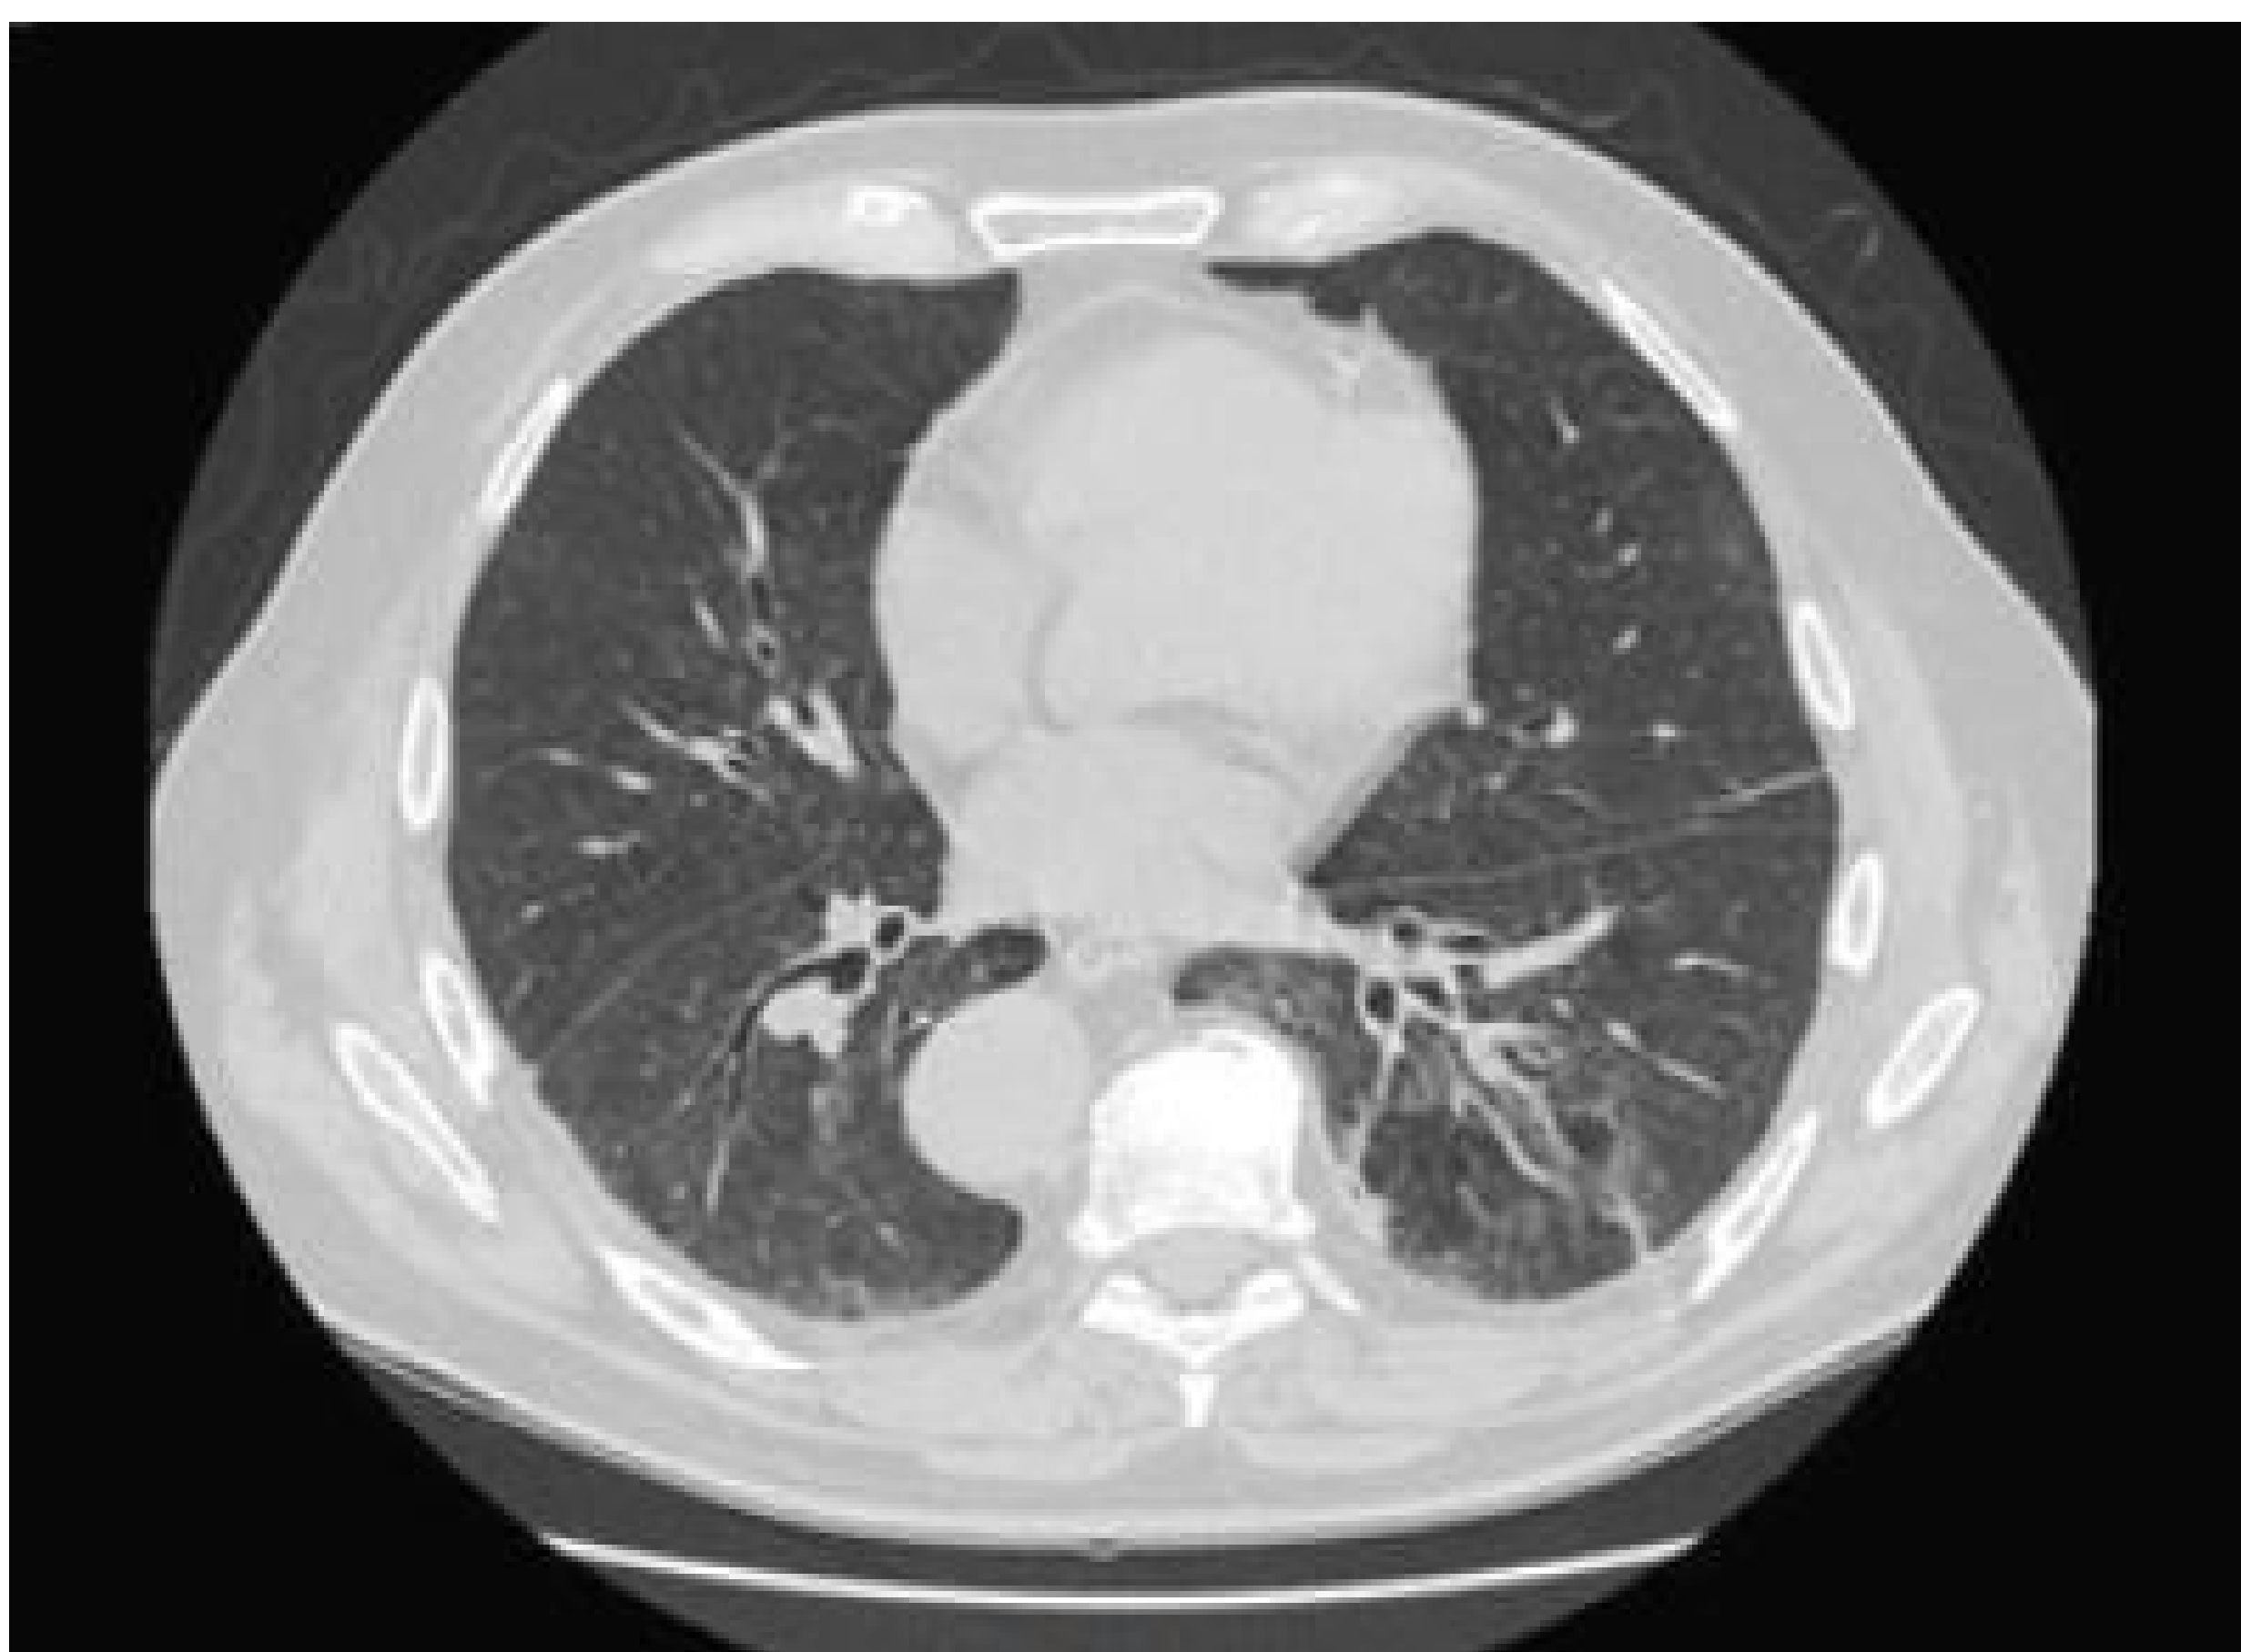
High Resolution Chest Computed Tomography of 74 yrs old man showing lower lobe lobular bronchiectasis and polished glass areas in subpleural site
